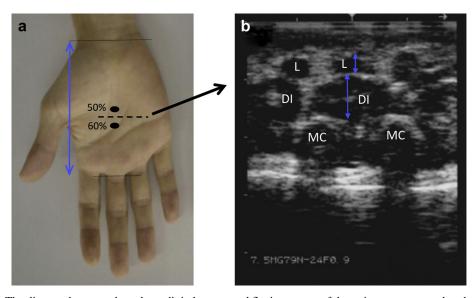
(a) The distance between the palmar digital crease and flexion crease of the wrist was measured to determine the measurement site. (b) Typical ultrasound image (young woman, 21 y) revealing transverse scan on the palm at 55% distal between two anatomic landmarks. DI = dorsal interosseous; L = lumbrical; MC = metacarpal bones.
